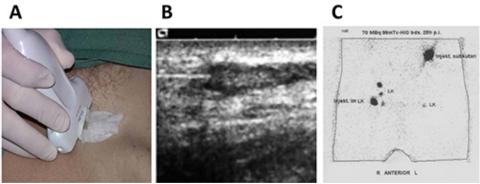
Intralymphatic vaccine administration in humans. Intralymphatic vaccine administration in humans is done by allocating subcutaneous lymph nodes with the aid of ultrasound. The hypodermal needle is inserted into the paracortex of the lymph node, and the injection can be controlled by observation of immediate lymph node swelling in the ultrasound image. (A) The intralymphatic injection is guided by ultrasound. (B) Ultrasound image showing needle (straight whitish line) inserted into the paracortex of the lymph node. (C) Biodistribution after injection of radioactively labelled protein into an inguinal lymph node ("Injekt im LK"; right anterior) and subcutaneously ("Injekt subkutan"; left anterior) in man. Click here to view larger image.
